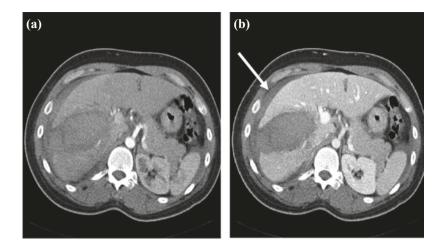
Axial multiphasic CT liver (arterial and venous phases) of a patient following blunt trauma in a cycling accident. This is classified as AAST grade IV (laceration involving 25–75% of hepatic lobe). No active haemorrhage is demonstrated, however there is a crescent of high attenuation material surrounding the liver (see arrow), consistent with haemoperitoneum
